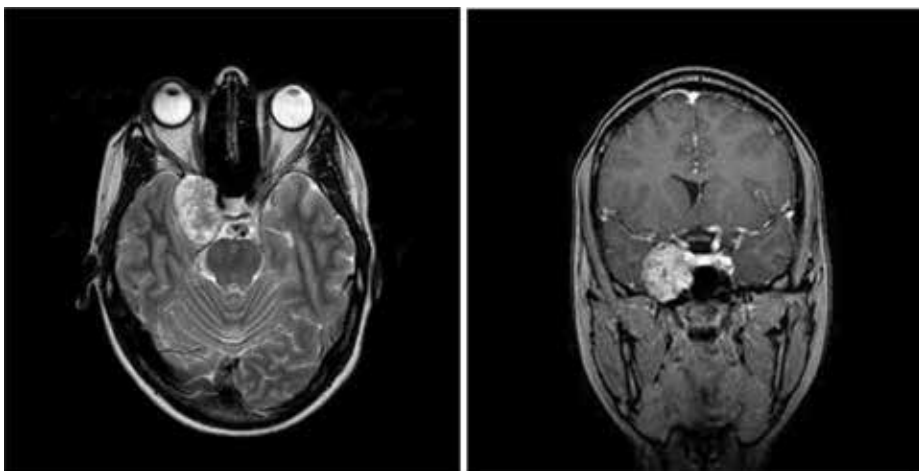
From the left to the right, preoperative T2-weighted image (axial) and T1 coronal with gadolinium of a type a right trigeminal schwannoma operated in our institution.
